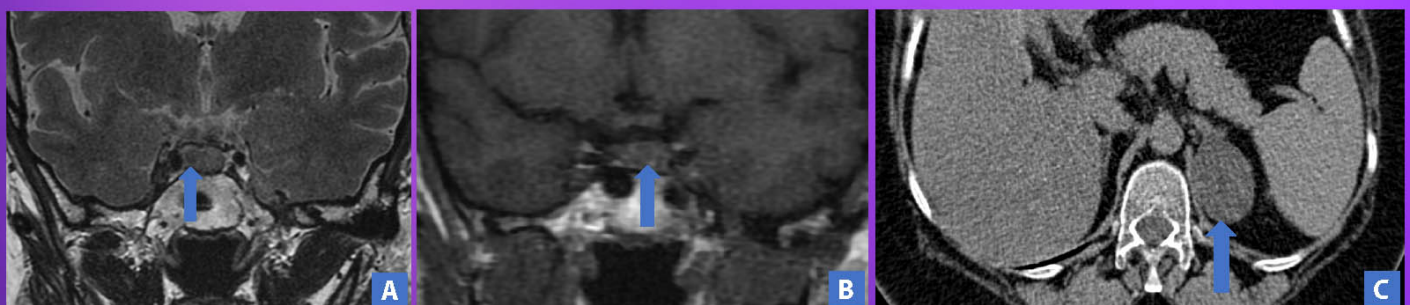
A: Case 1 Pituitary MRI coronal T2 image. B: Case 2 Pituitary MRI coronal T1 image. C: Case 3 abdominal CT image.
